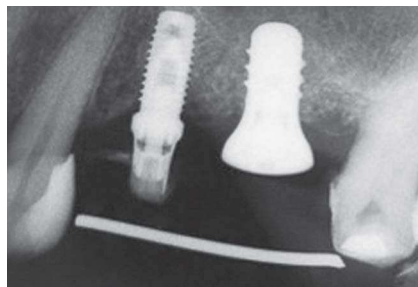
Radiographic image after healing.
